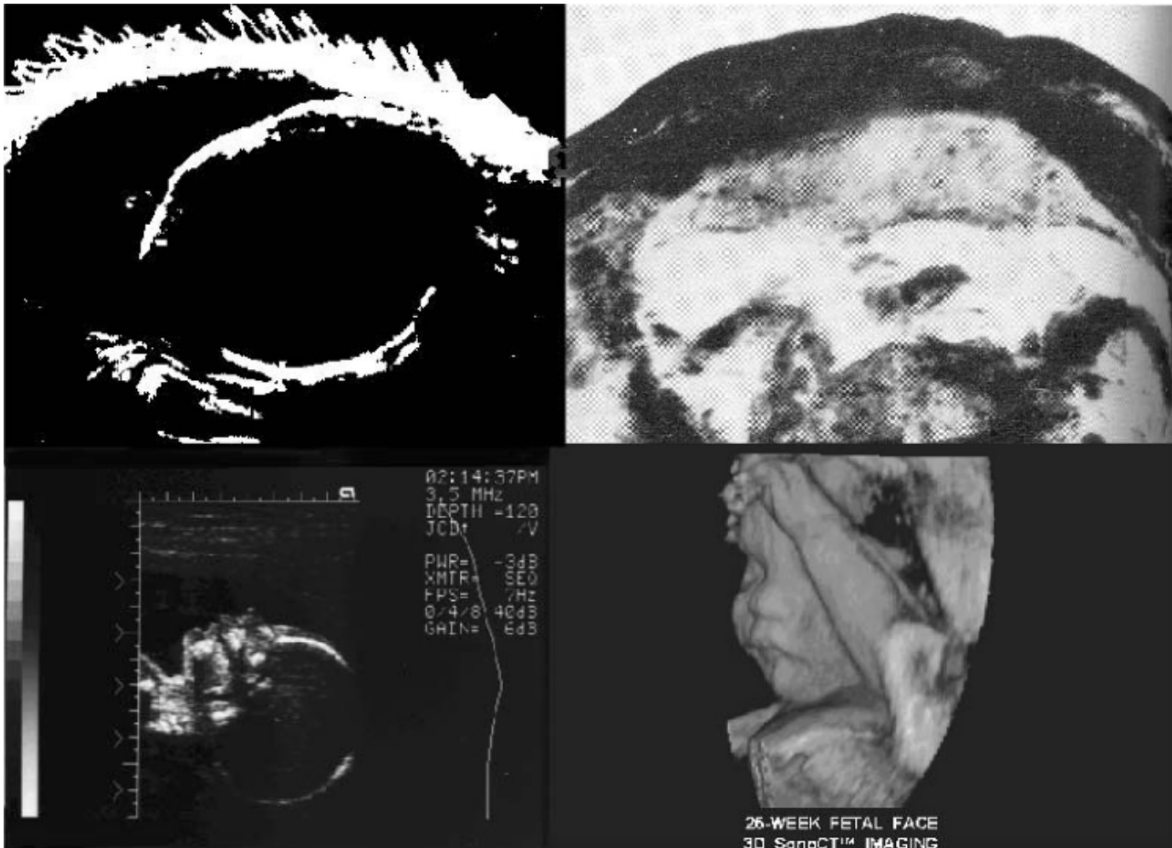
The development of medical ultrasound imaging as shown in fetal images. (Upper left) Fetal head black-and-white image from 1960. (Upper right) Early grayscale negative image of fetus from the 1970s. (Lower left) High-resolution fetal profile from the 1980s. (Lower right) Surface-rendered fetal face and hand from 2002 (Szabo, 2014, chapter1).
